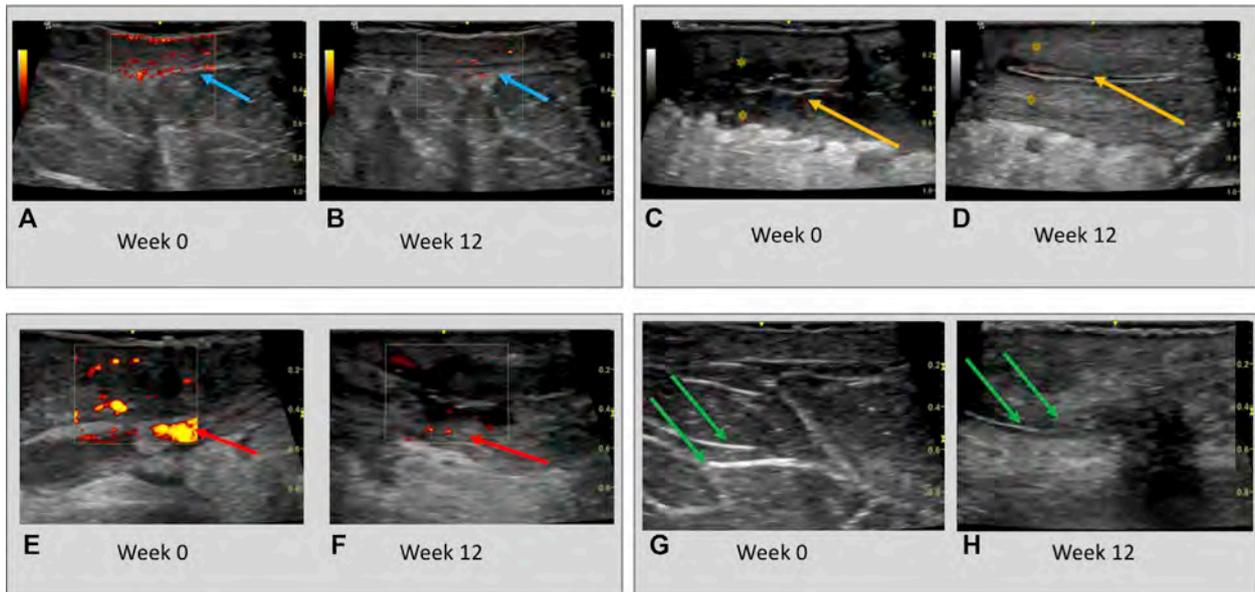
A, C, E, and G, Ultrasonographic changes at baseline and (B, D, F, H) after 12 weeks of treatment with brodalumab. Dermal Doppler ultrasonography intensity in lesional dermal tissues at (A) baseline (blue arrows) is significantly attenuated at (B) week 12 (blue arrows) of therapy. The diameter of draining tunnels (yellow arrows) and surrounding edema (yellow asterisk) at (C) baseline is also reduced at (D) week 12. Similarly, Doppler intensity (red arrows) surrounding (E) epithelialized dermal tunnels (F) reduces at week 12 compared with baseline. The diameter and echogenicity of dermal tunnels (green arrows) is also (H) attenuated at week 12 compared with (G) baseline.
